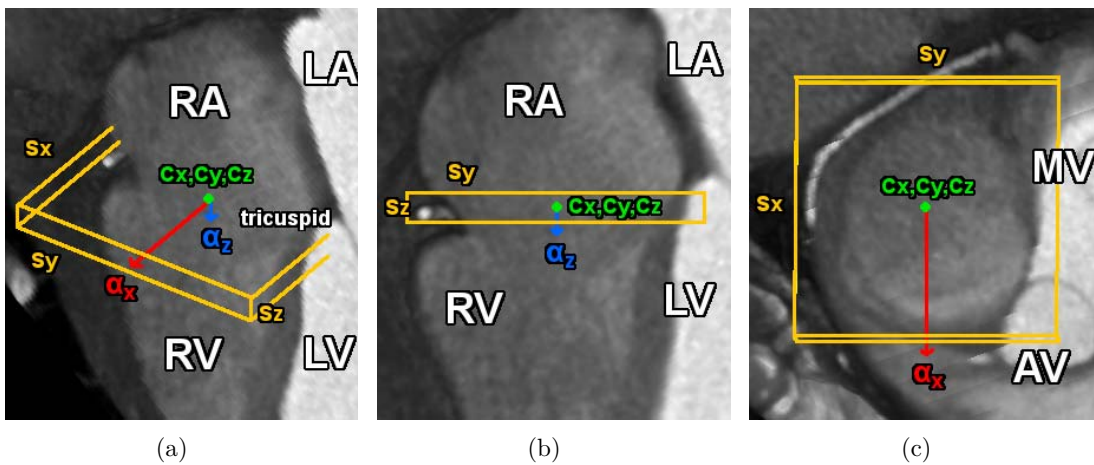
Similarity transform represented as a bounding box around the tricuspid valve from cardiac CT. (a) Perspective view; (b) Long Axis; (c) Short Axis.
